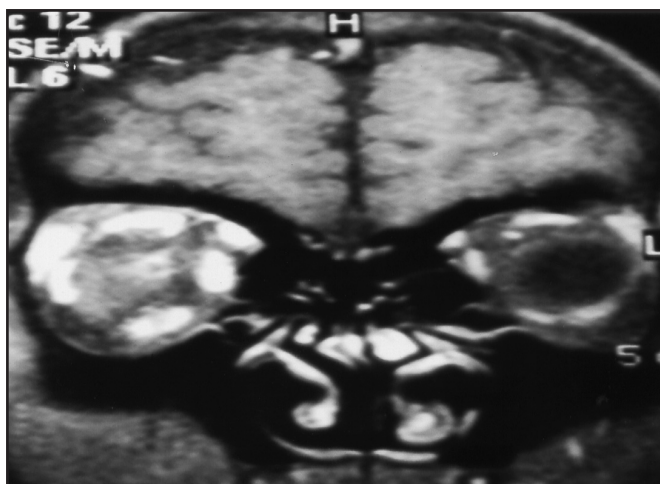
MRI picture of the orbit, coronal view reveals gross enlargement of all the extraocular muscles of the right eye
